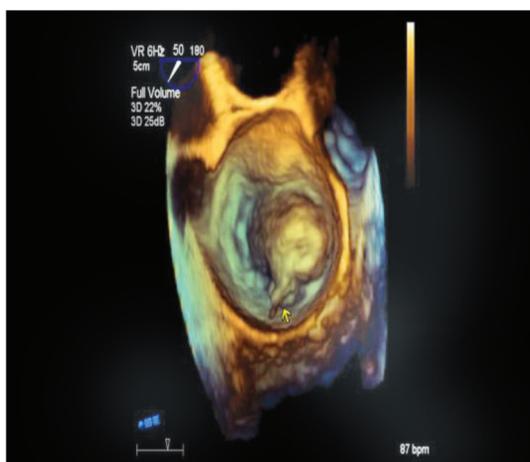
Transesophageal 3D zoom imaging of the mitral valve in en face view from the left atrial side. Arrow points to a flail A2 scallop with a ruptured chord.
